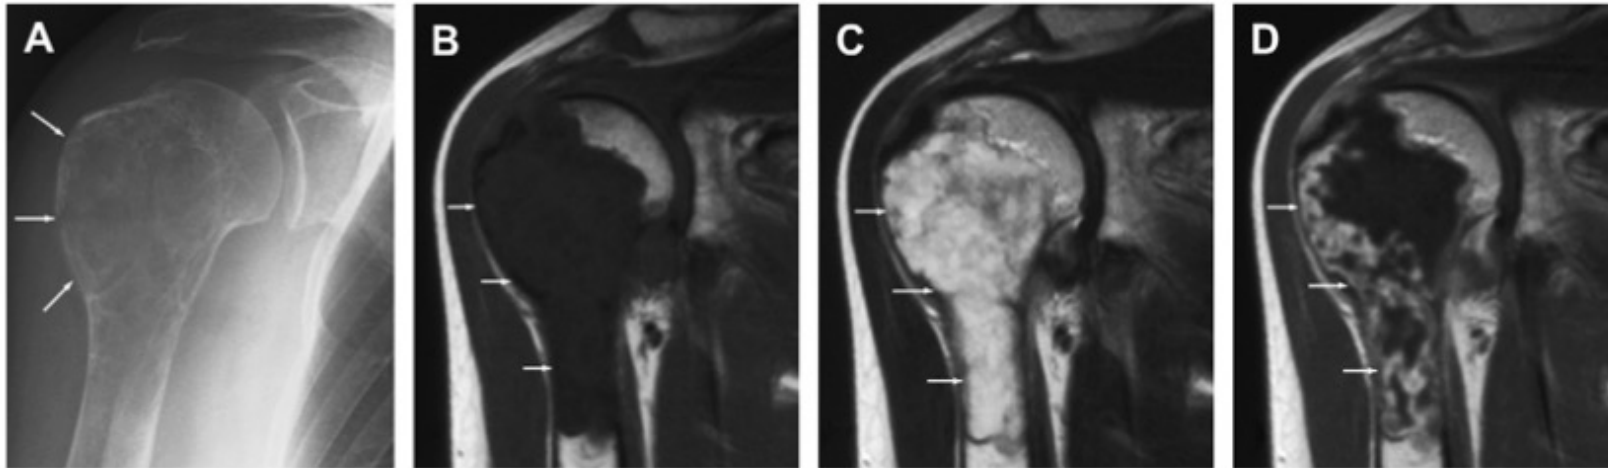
A 61-year-old female suffering from chondrosarcoma. The ballooning of the lateral cortex with destruction of the bony trabeculae due to chondrosarcoma were seen in the proximal part of the humerus (A). However, because the tumor was localized inside the humerus (*arrows*), it was overlooked and misdiagnosed with frozen shoulder syndrome by the primary physician. She underwent a conservative therapy for 7 months as frozen shoulder syndrome, then underwent surgical resection with a wide-margin (A, plain x-ray; B, T1-weighted image in the oblique coronal plane; C, T2- weighted image in the oblique coronal plane; D, T1-weighted image with gadolinium enhancement in the oblique coronal plane).
